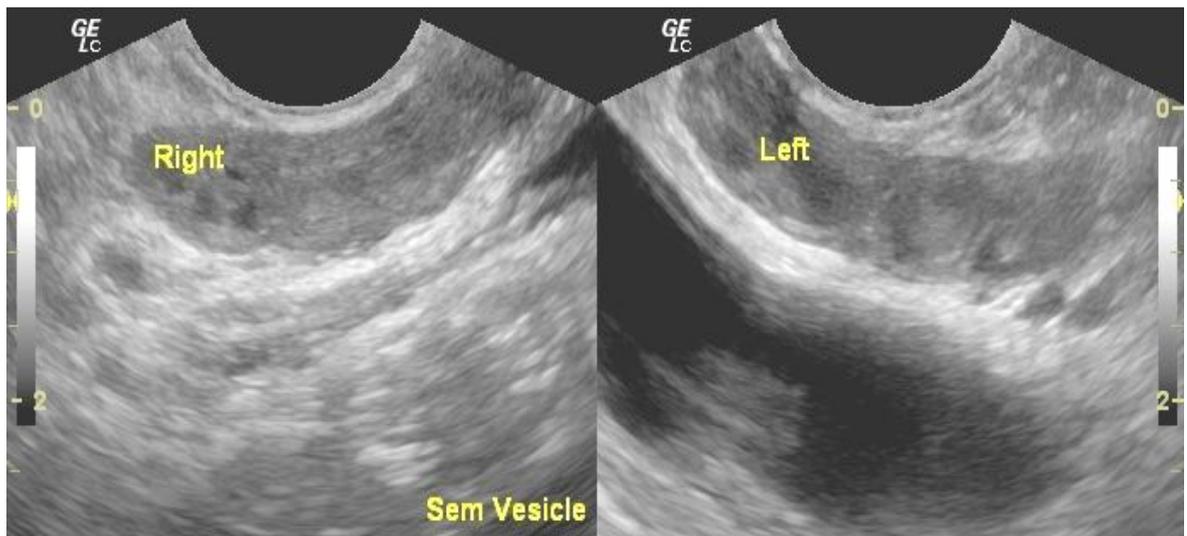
Image of ultrasound scanning of normal seminal vesicle Right and Left.
